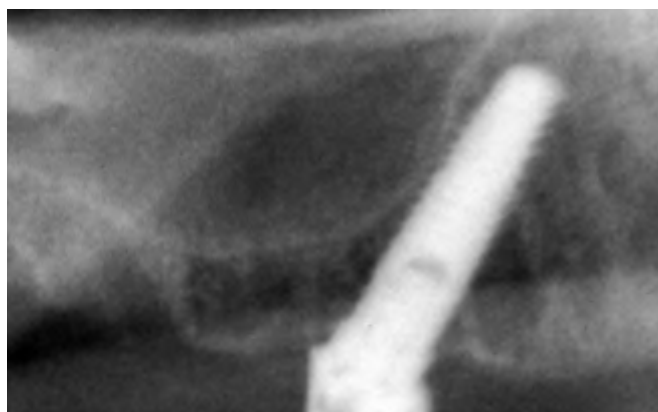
Radiograph after the right posterior tilted implant was placed. Note that the implant was parallel to the anterior wall of the maxillary sinus.
